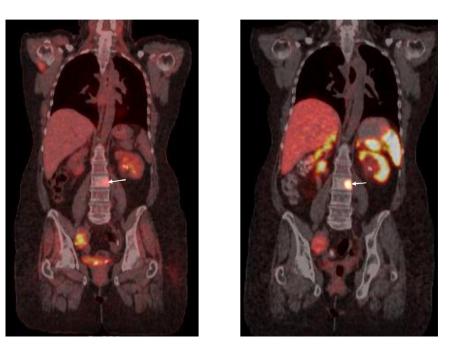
(A) Whole body F18-FDG PET/CT showed metabolic activity of the L3. (B) Whole body Ga68 DOTA TOC PET/CT showed more metabolic activity in comparison to the F18-FDG PET/CT scan (note the arrow).
